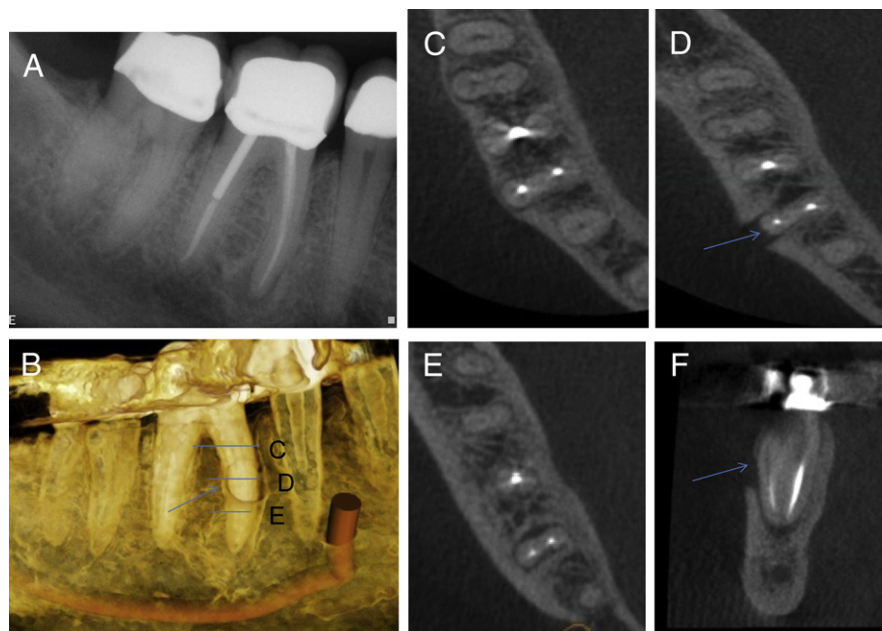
(A) Periapical radiograph of tooth #30. (B) 3D reconstructed view demonstrating the mid-root buccal defect (arrow). Lines correspond to the axial section views (C–E). Note axial view demonstrating the mid-root buccal bone loss (arrow) in (D). (F) Coronal view demonstrating the mid-root buccal bone loss (arrow).
